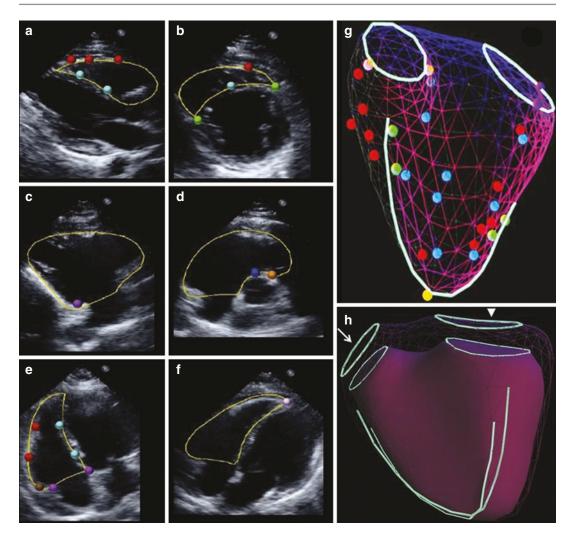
Use of knowledge-based reconstruction for 3-dimensional modelling of the right ventricle from 2-dimensional transthoracic echocardiographic data. Panels a–f show the several views of the right ventricle obtained with 2-dimensional transthoracic echocardiography. The several anatomical landmarks are marked
